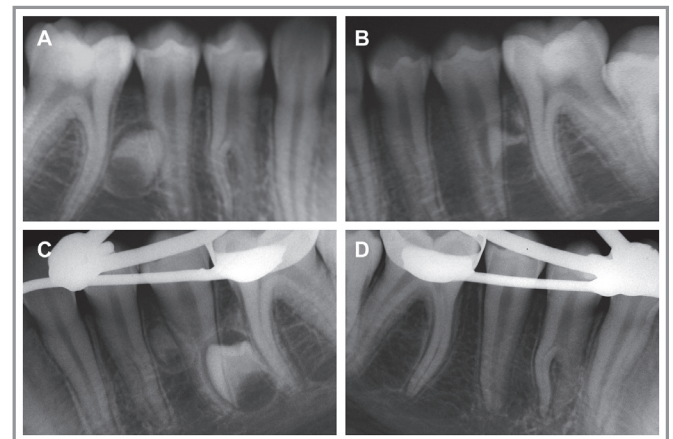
(A and B) Periapical radiographs revealing 2 bilateral supernumerary teeth (ST) in the mandibular premolar region. (C) Two years later, the patient developed 1 more ST in the mandibular premolar region, on the left side. (D) No recurrence or formation of new ST has been observed on the right side.
